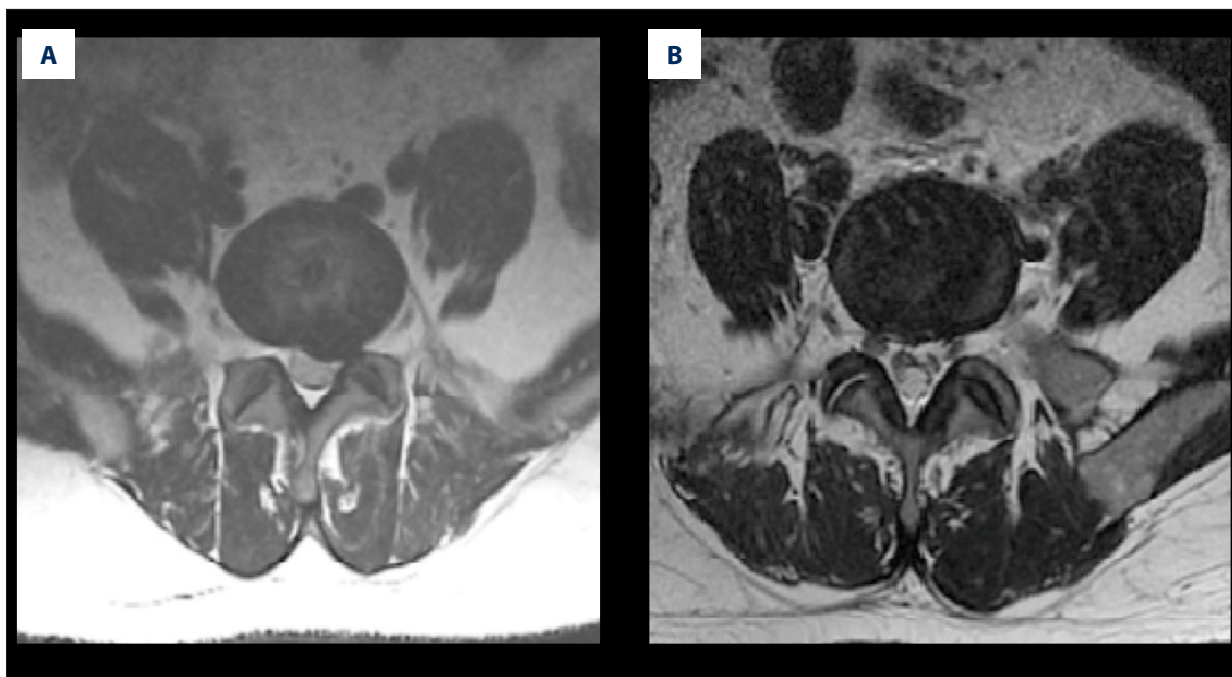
Axial images of preoperative MRI examination (A) showing significant regression of disc herniation and axial images of postoperative MRI examination (B) showing significant disappearance of disc herniation.
